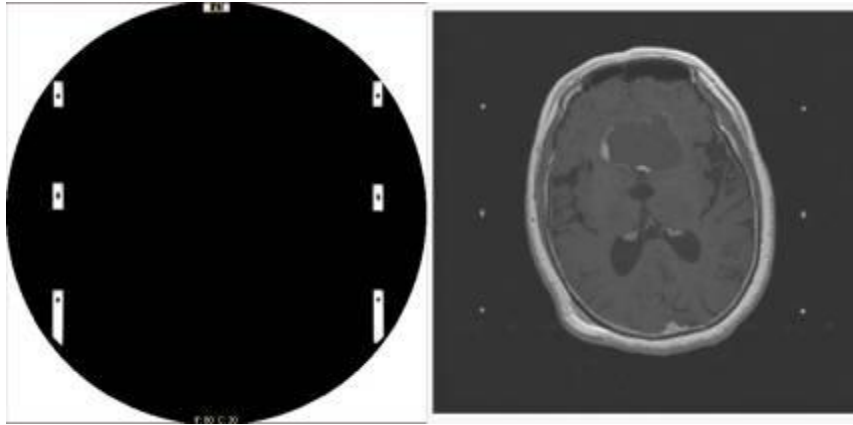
CT and MR slices at the same head position (same z direction)
